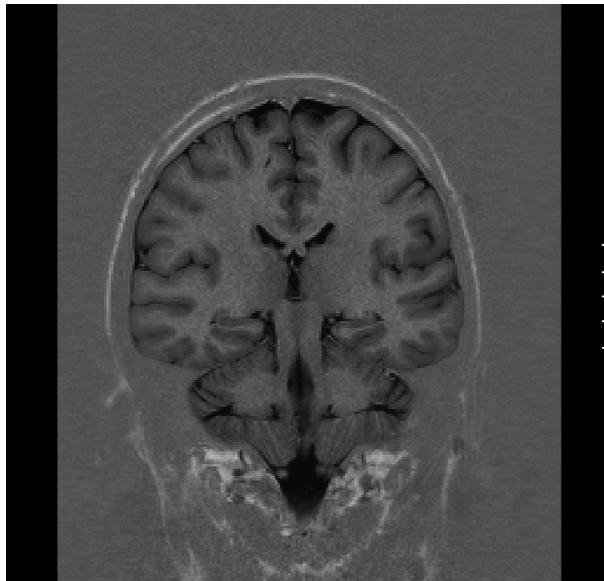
MRI image of the brain. Compare with Figure 12.15. The MRI image shows differences due to hydrogen concentration rather than tissue density, making the bony part of the skull transparent and having a different contrast pattern than the CT image. (Image courtesy of Siemens Medical Systems.)
